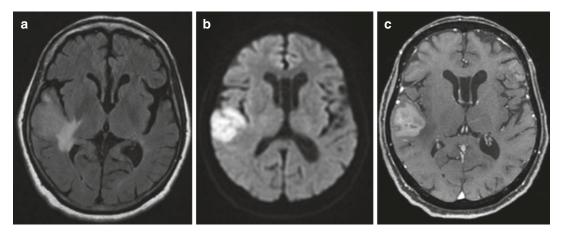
(a) Axial FLAIR, (b) axial DWI and (c) axial post contrast images of the brain showing an ill-defined lesion in the right temporal lobe displaying hyperintense
